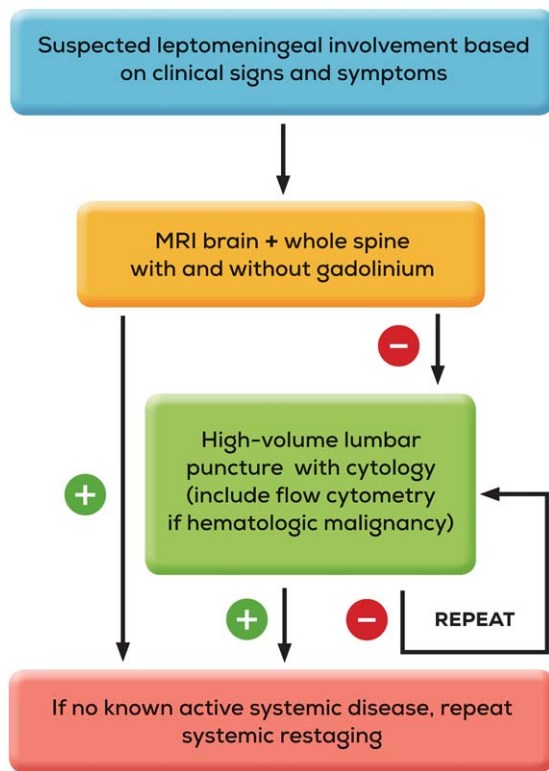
This is a diagnostic algorithm of the current study. MRI indicates magnetic resonance imaging.
